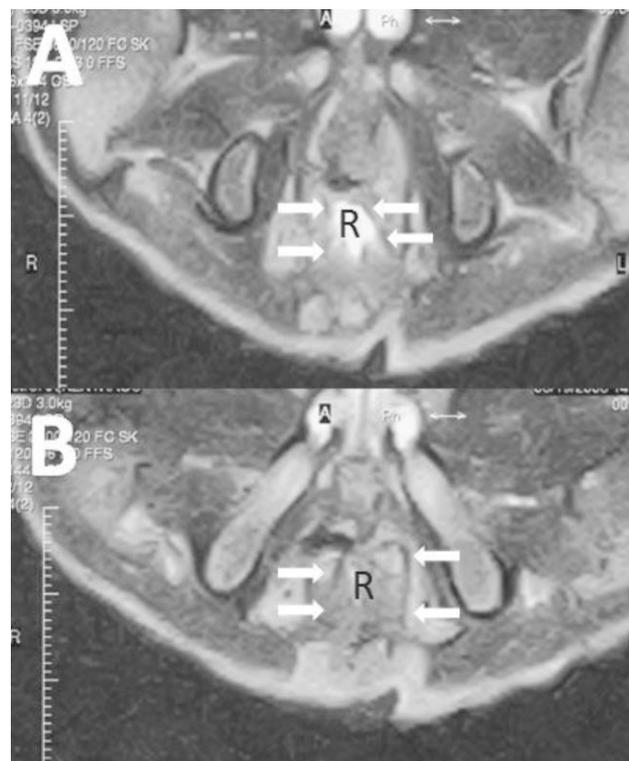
Postoperative axial T2-weighted magnetic resonance imaging of the pelvis. Muscles can be seen around the rectum. Normally they are symmetrical. Malpositioning of the rectum and muscle (arrows) with a right-left difference at the M-line (A) and I-line (B) in patient B. R: rectum.
